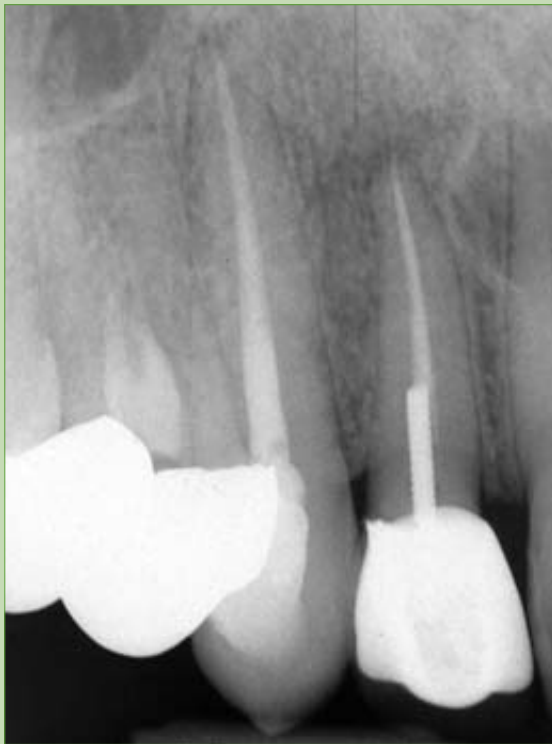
Initial radiograph of root canal recently completed (1995).
